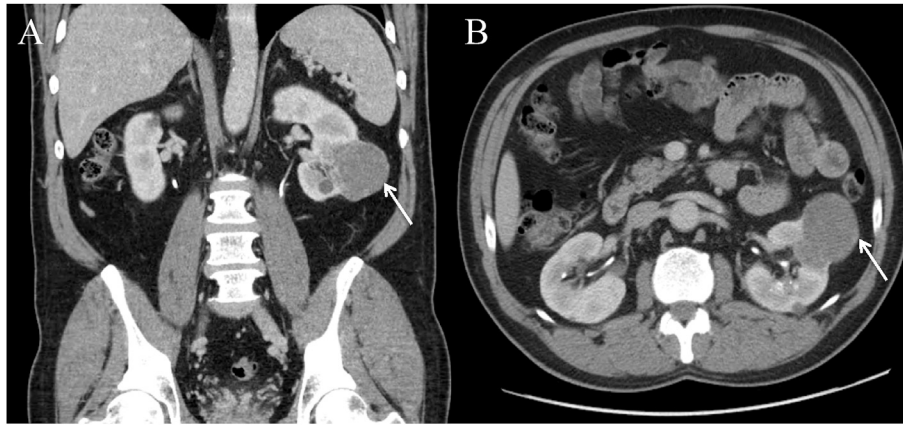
Preoperative computed tomography (A) coronal (B) axial demonstrating a 5.6×4.4 cm exophytic mass in the left renal midpole anterior cortex suspicious for renal cell carcinoma.
